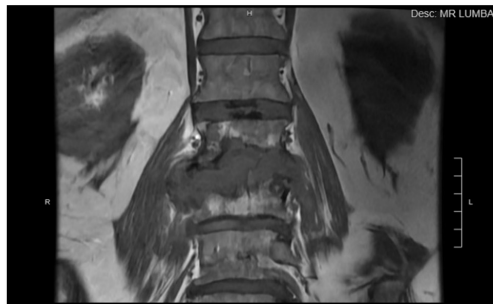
MRI Lumbar Spine. T1-weighted axial views showing destruction of L2-3 disc and vertebral body
